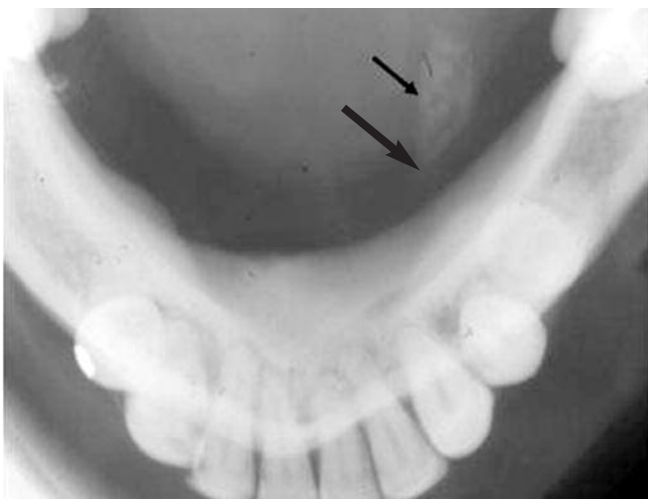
Plain x-ray demonstrating an intra-oral lesion (arrowed)
